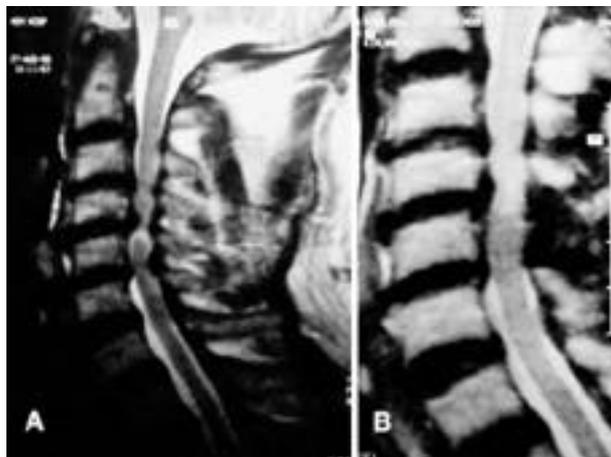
73-year-old man. A. preoperative sagittal MRI. B. postoperative sagittal MRI.
